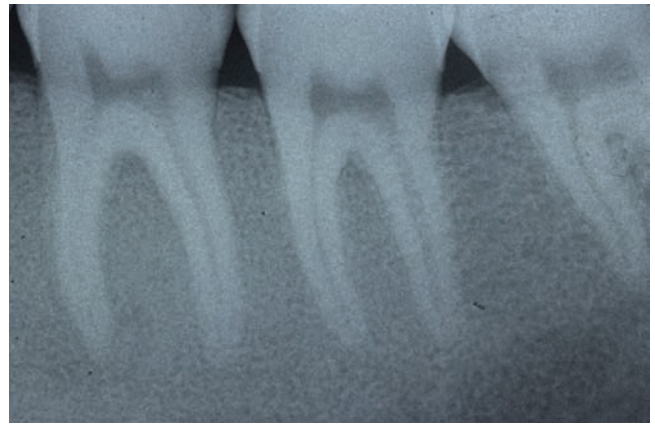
Fibrous dysplasia. Radiograph of the mandible showing the characteristic ground-glass appearance of the bone in fibrous dysplasia. (Courtesy of Dr. Charles Dunlap.)
